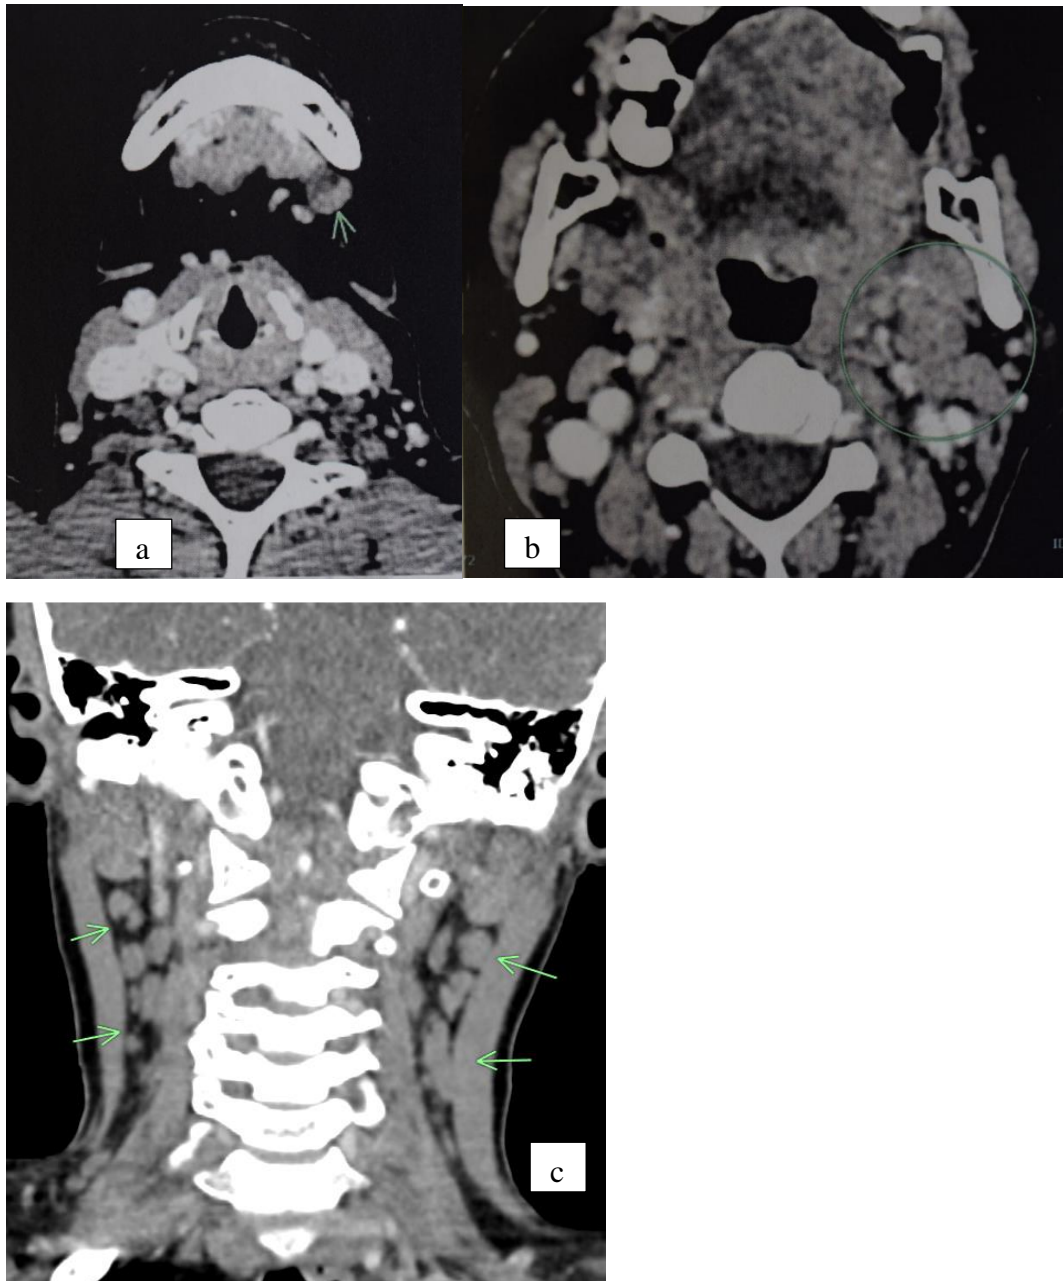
3 CT scans from the study, soft tissue windows; a)- Axial view showing an enlarged node left level Ib. b) Axial view showing multiple enlarged and matted lymph nodes left level II. c)- Coronal view showing increased number of enlarged nodes level II, III, IV bilaterally
